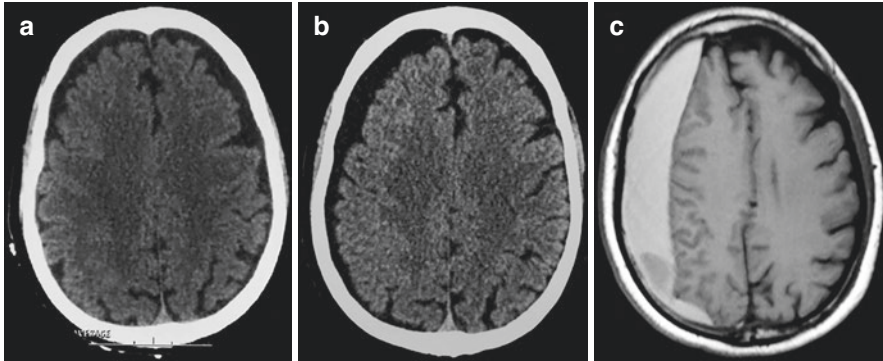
Case 1. Initial CT-scan in a 64-year-old man who sustained a mild head injury on the right side (a). Six weeks later, a small right subdural hygroma can be seen (b). Three months from trauma, chronic subdural hematoma was evident on T1-weighted MRI (c)
